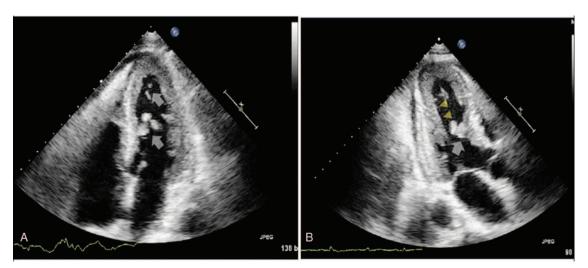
Transthoracic echocardiography showing endomyocardial fibrosis and diffuse intracardiac thrombus. (A) Four chamber view showed diffuse floating intracardiac thrombi (arrows). (B) Apical long axis view showed increased global wall thickness, especially apical and middle segment of the posterior wall (arrowheads) and floating thrombi (arrow).
